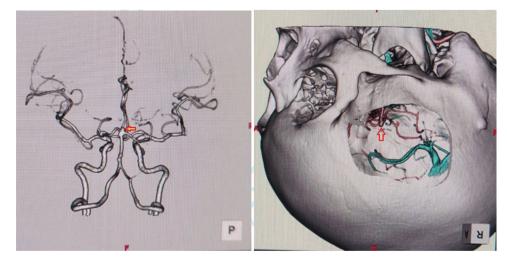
From left to right; Preoperative 3D CTA shows the basilar tip aneurysm (red arrows) and surgical approach (right pterional transsyvian approach).
